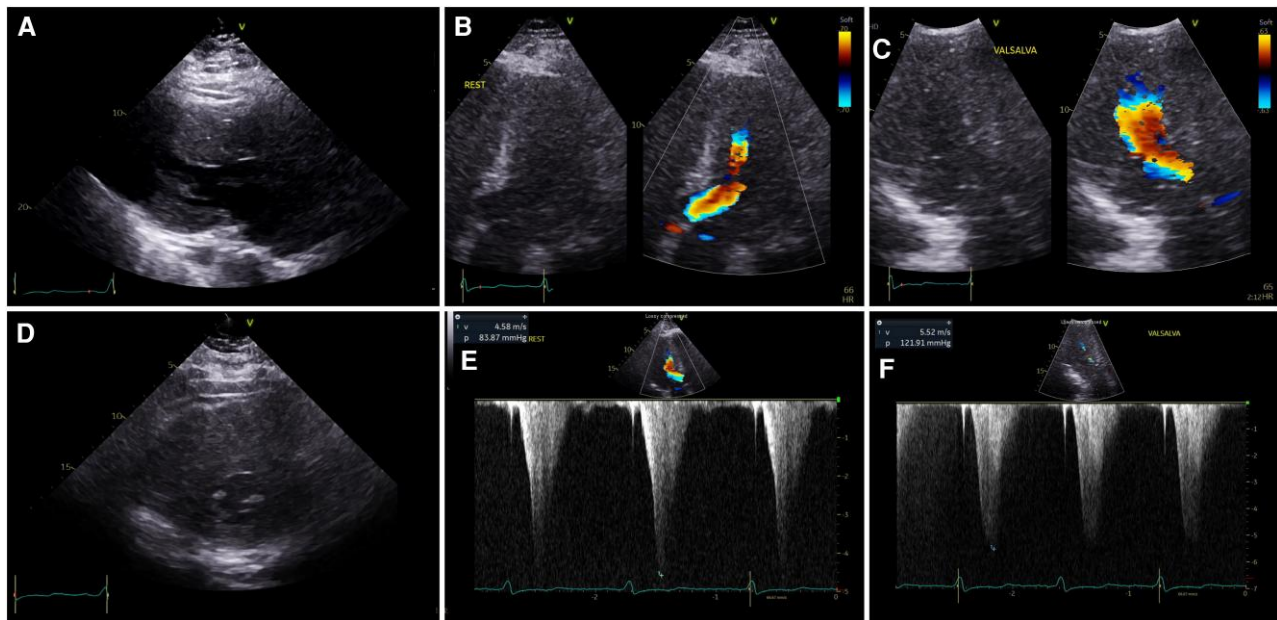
Baseline echocardiographic findings before mavacamten initiation. (A) Parasternal long-axis view showing asymmetric septal hypertrophy. (B, C) Apical views with colour Doppler at rest and during Valsalva manoeuvre demonstrating turbulent LVOT flow. (D) Parasternal short-axis view showing marked asymmetric septal hypertrophy and systolic cavitory obliteration. (E, F) Continuous-wave Doppler demonstrating a resting LVOT gradient of 84 mmHg and an increased gradient of 122 mmHg during a Valsalva manoeuvre. LVOT, left ventricular outflow tract.
